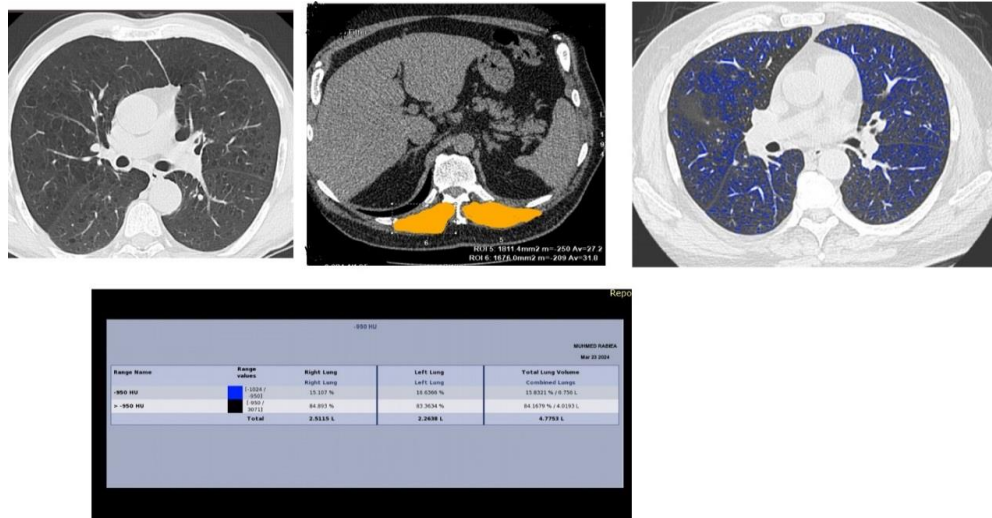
Representative chest computed tomography (CT) image used to measure the cross-sectional area of erector spinae muscles (ESMCSA). The manually selected area (yellow) is used to measure ESMCSA using the computer software and the table shows the low attenuation area percentage (LAA%) in a mild COPD case.
